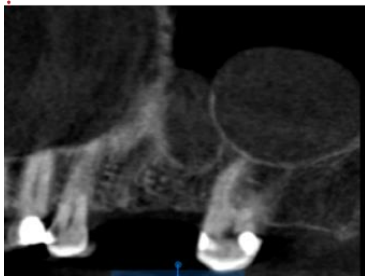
CBCT image of teeth #25 and #26
